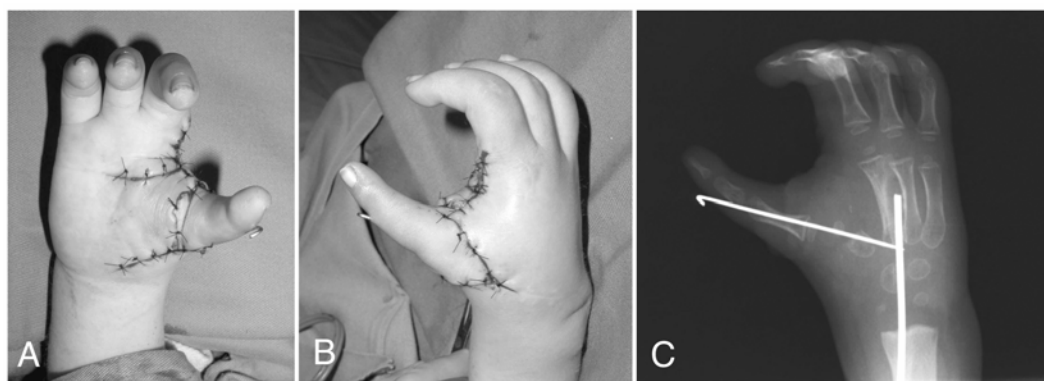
A–C, Pollicization at 31-months-old. A, B, Appearance immediately after pollicization. C, X-ray film immediately after the operation.
